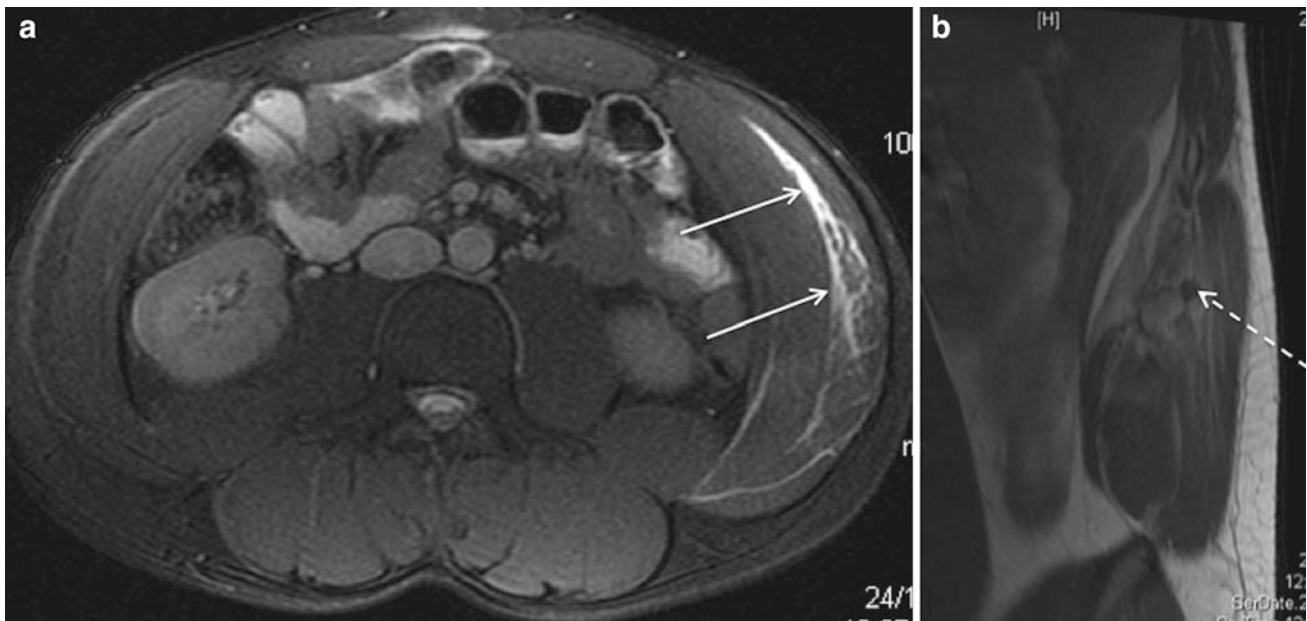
Axial proton density weighted MR image with fat saturation (a) in a professional cricket player demonstrates an acute side strain, with feathery intramuscular oedema in the external oblique (arrow).
